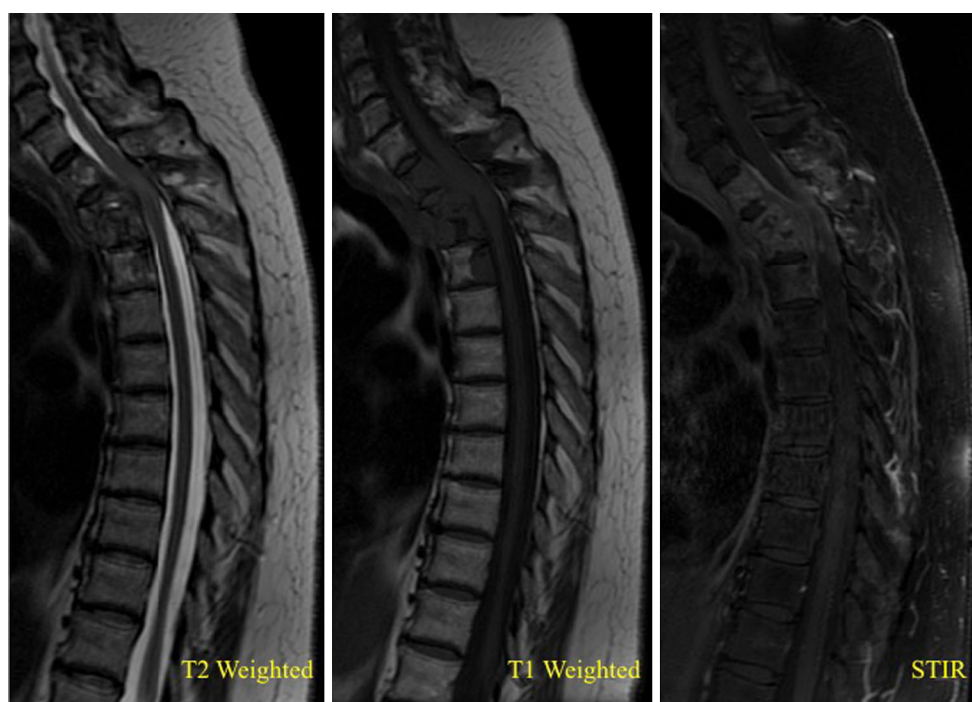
Sagittal MRI scan of the thoracic spine demonstrating the upper thoracic spine involvement
